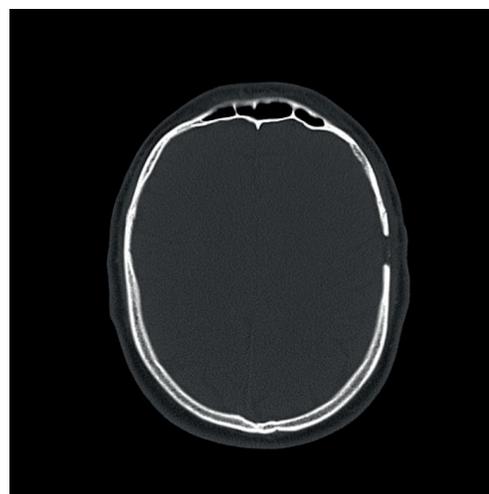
A) Control CT of the patient taken after treatment. No pathological findings were observed.
